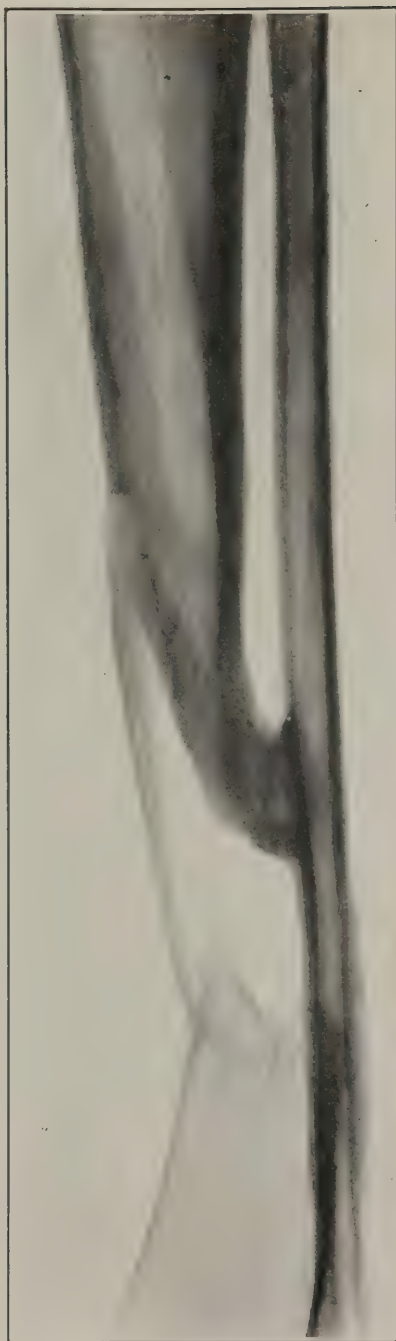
Case 14. Roentgenogram of graft six weeks after operation
